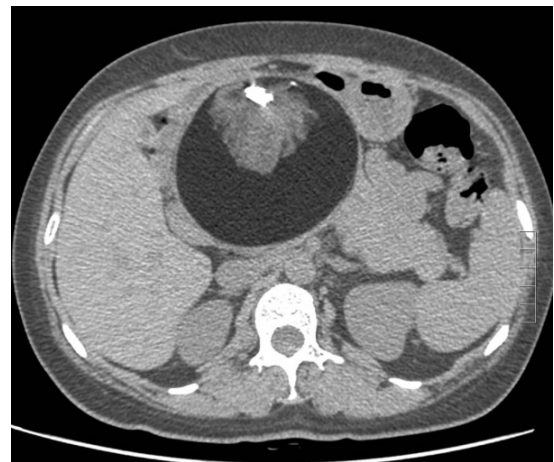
Vertical abdominal CT scan.
